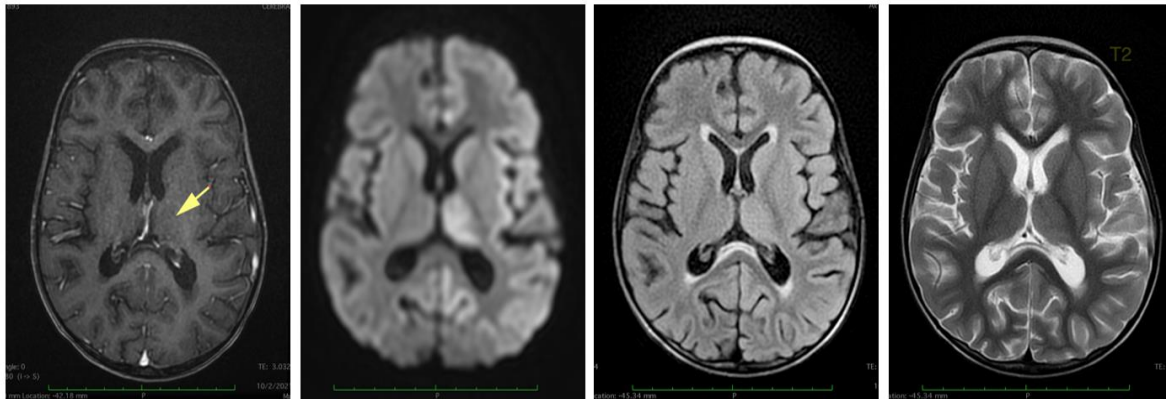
Brain angio-MRI: left thalamic hyper intensity (Flair and T2), without perilesional edema, without significant improvement after injection and without mass effect on the midline also note a diffusion hyper signal affecting the left cuneus and the cingulate gyrus.
